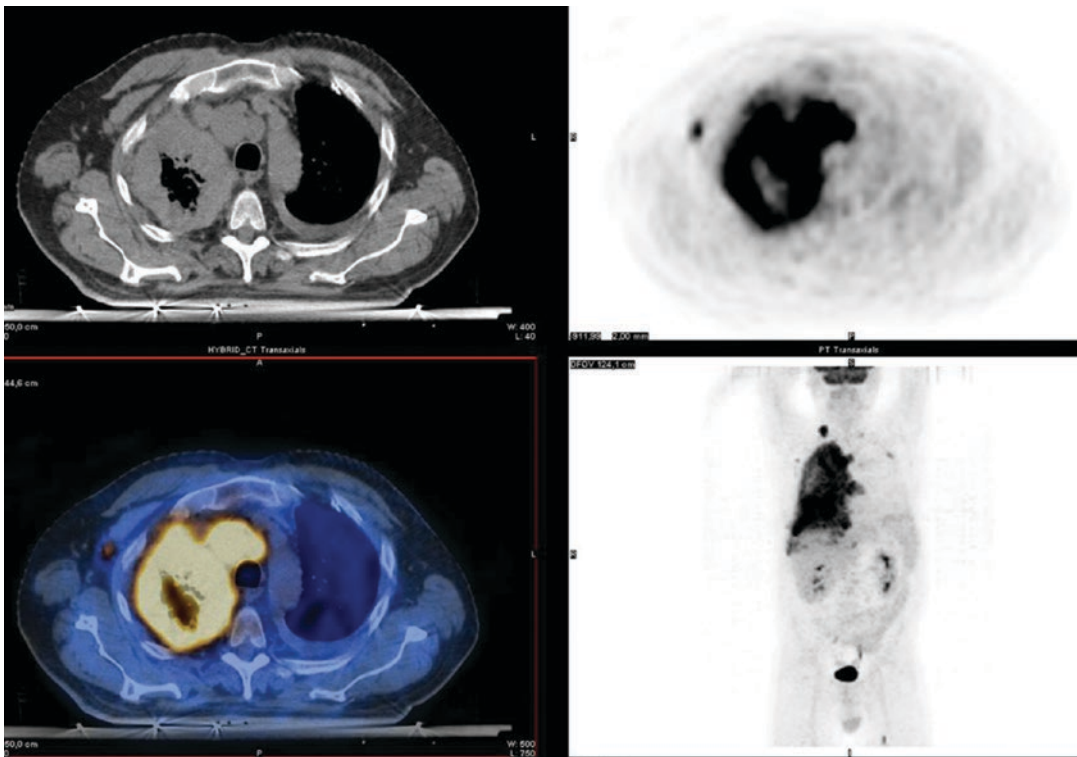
PET/CT discriminate locally advanced disease. This practice permits the description of mediastinum structures invasion, which could be underestimated by CT
